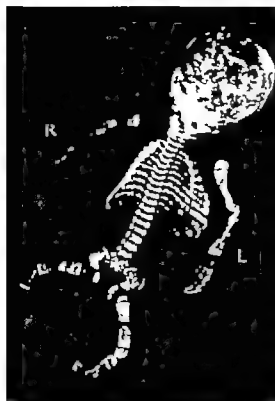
Roentgenogram of the complete skeleton of a stillborn child with osteogenesis imperfecta. (From Knaggs *Diseases of Bone*, Wood, Baltimore, 1928 p 376)
